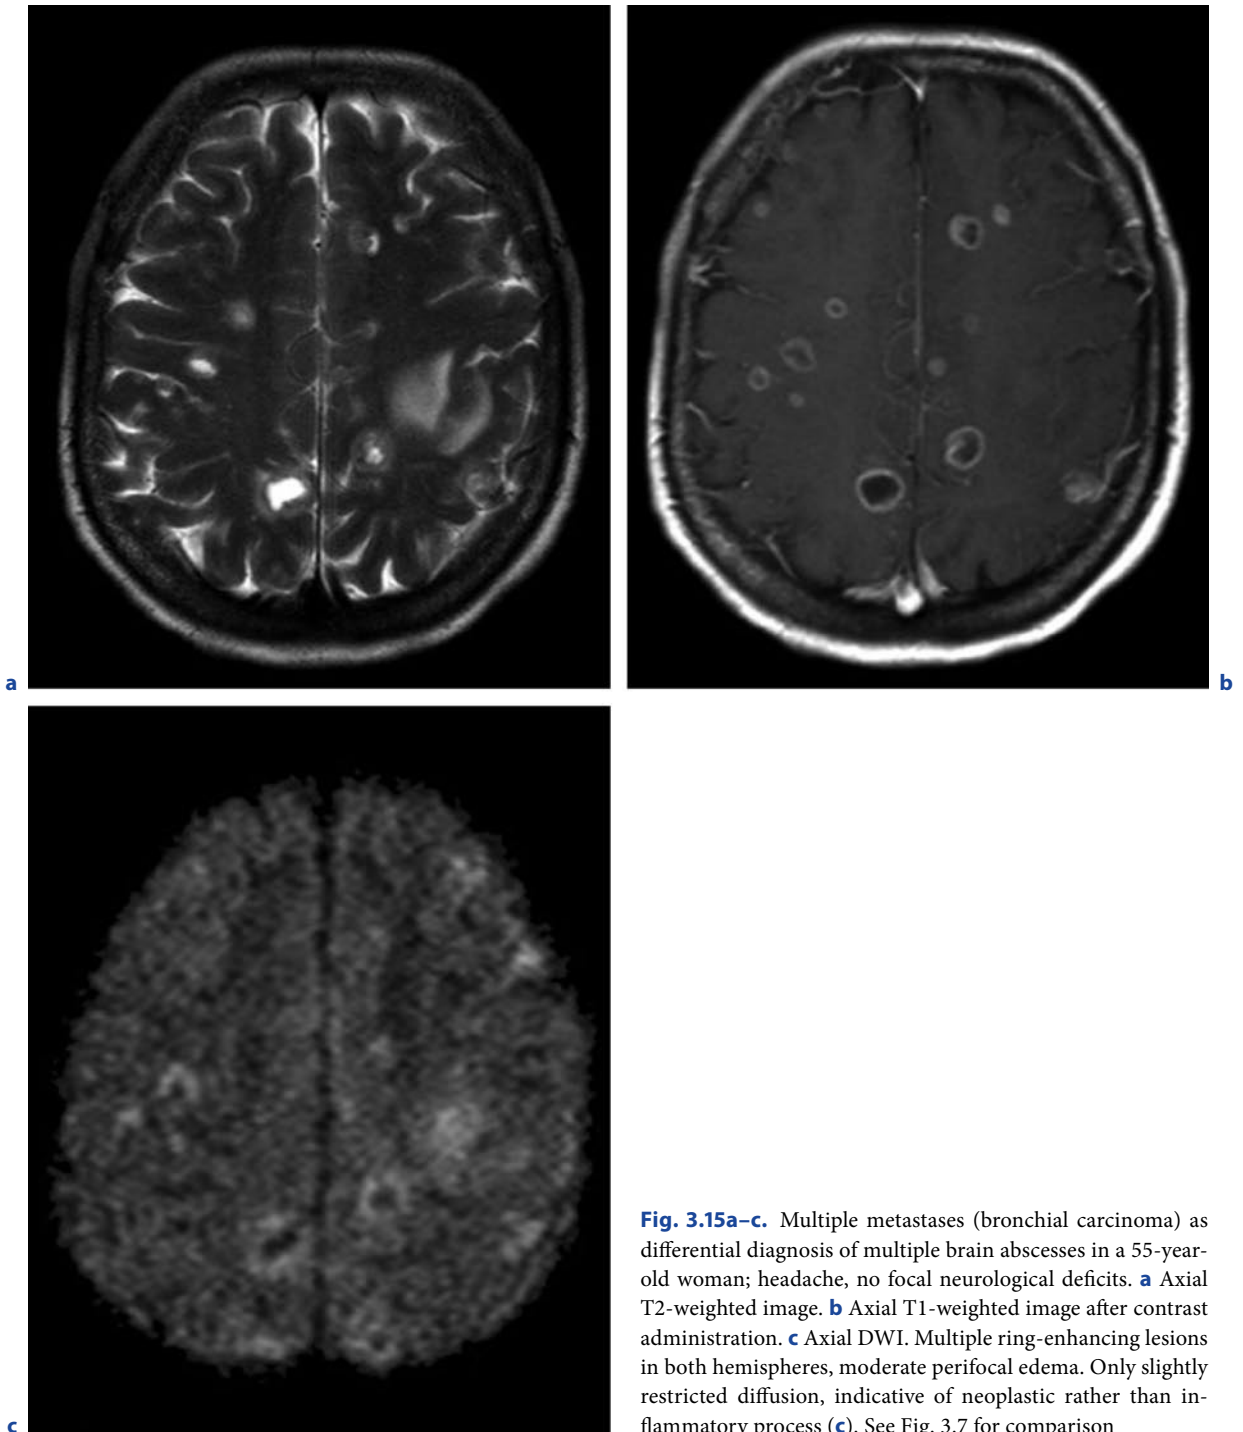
Multiple metastases (bronchial carcinoma) as differential diagnosis of multiple brain abscesses in a 55-year-old woman; headache, no focal neurological deficits. a Axial T2-weighted image. b Axial T1-weighted image after contrast administration. c Axial DWI. Multiple ring-enhancing lesions in both hemispheres, moderate perifocal edema. Only slightly restricted diffusion, indicative of neoplastic rather than inflammatory process (c). See Fig. 3.7 for comparison
